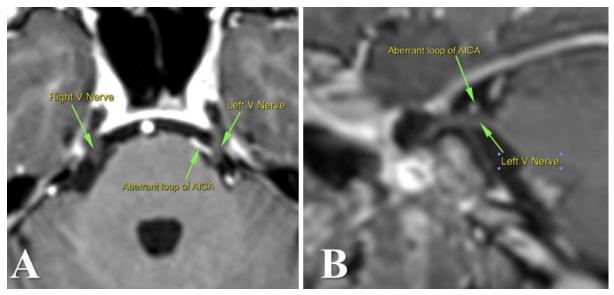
"MRI 3DT1 axial (A) and sagittal (B) sections showing the left trigeminal nerve compressed by an aberrant loop of the anterior inferior cerebellar artery; the right trigeminal nerve is normal," *Courtesy of Dr. B. Dobrovat* (from *Turliuc et al., 2016g*)
